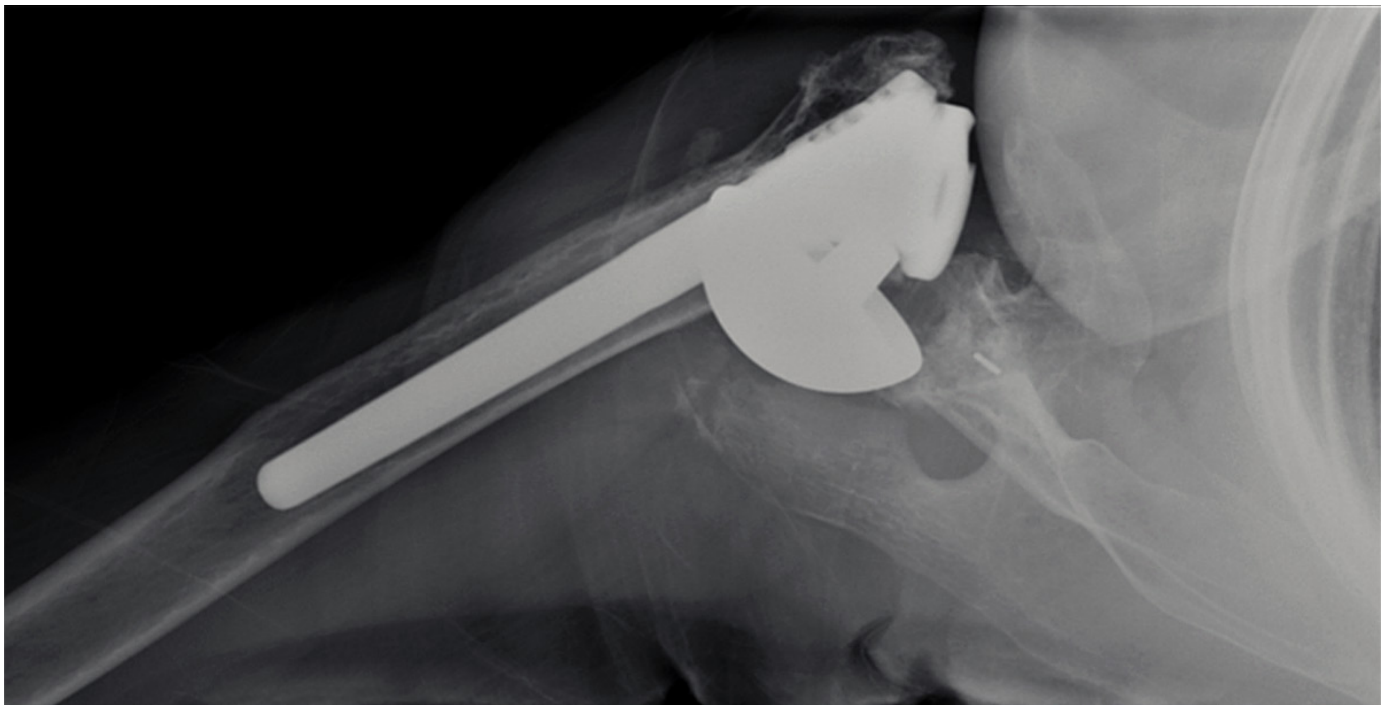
Plain films of the dissociated prosthesis at initial presentation
